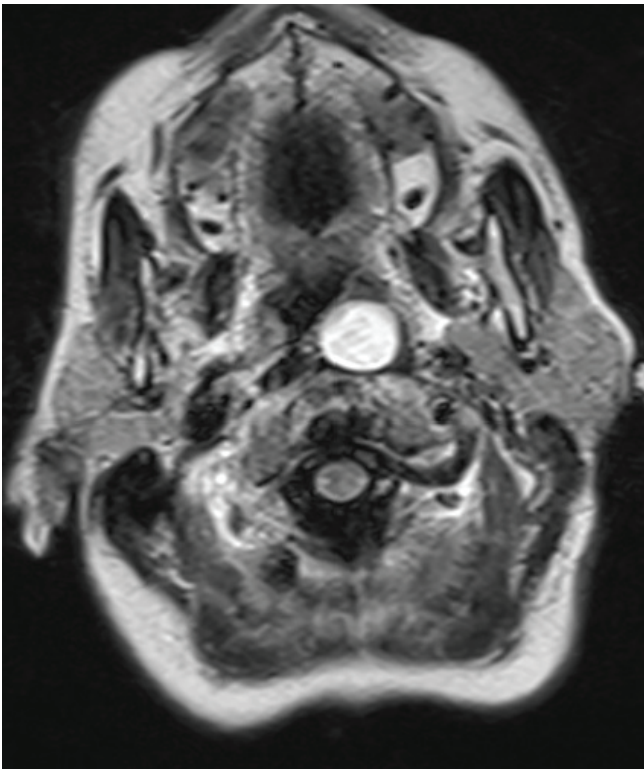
With axial FLAIR imaging, the lesion is also observed to have hyperintense signalling feature, similar to those observed with T1 and T2 weighted sequences.
